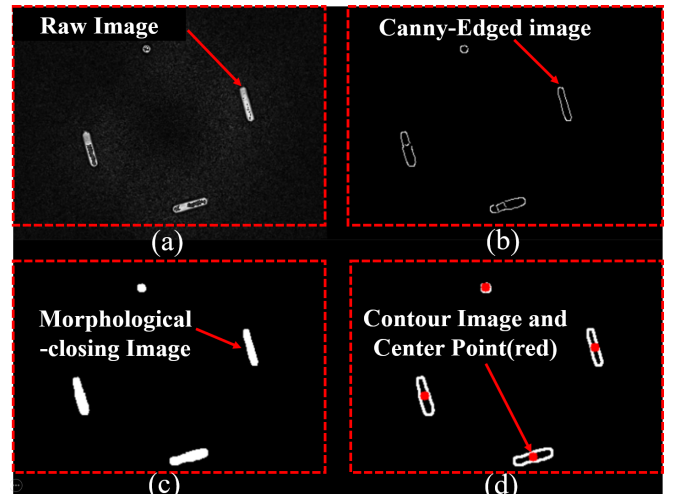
Procedure of the Welzl's algorithm and the results on MR images. (a) Raw image. (b) Canny-Edged image. (c) Morphological-closing Image. (d) Contour image and center point (red).
